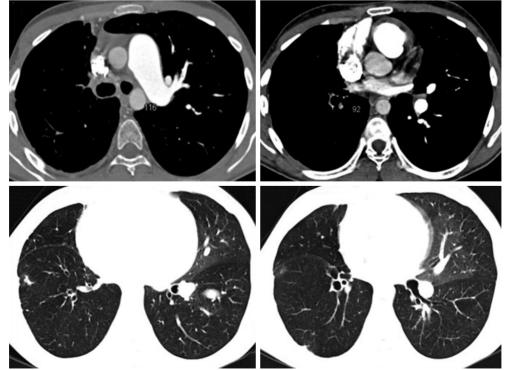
Pulmonary artery agenesis-thorax computed tomography image.
